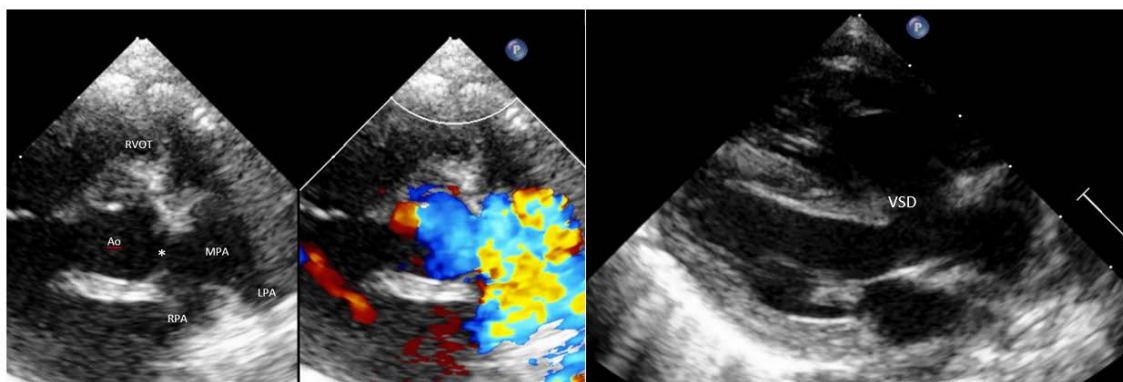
Echocardiography showing AP window (asterisk) type II with left-to-right shunt. RPA and LPA originate from the MPA. There was no flow from the right ventricle to MPA, indicating pulmonary atresia. There was coexisting subaortic VSD
